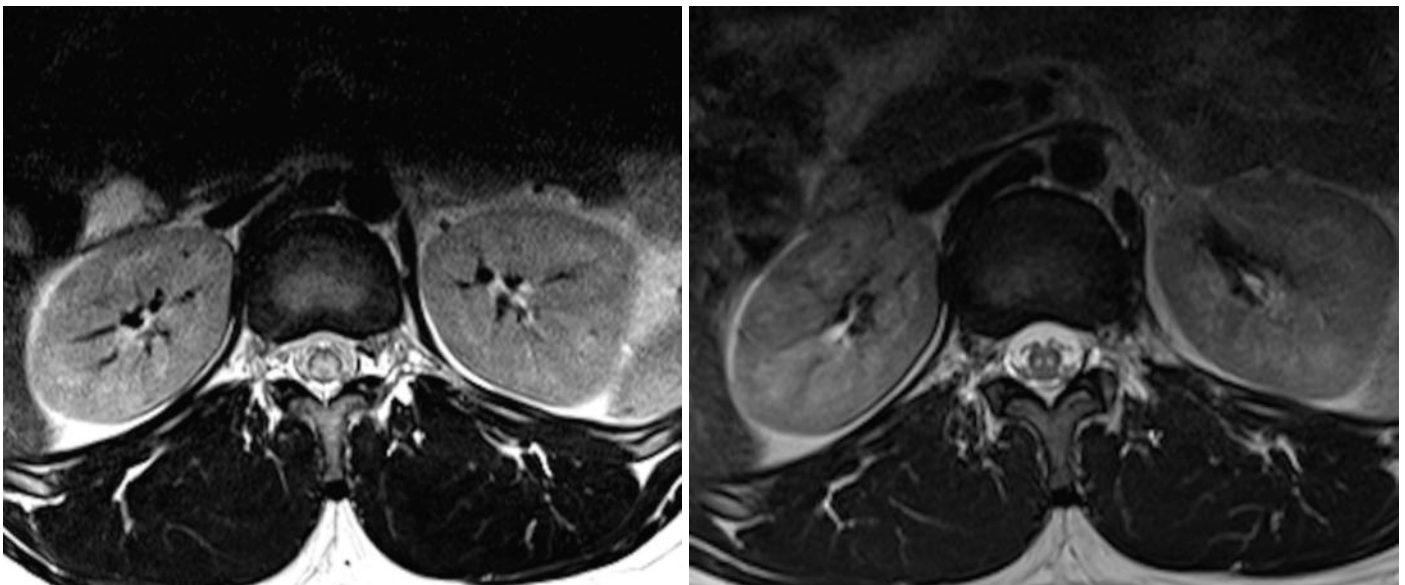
MRI comparison of the distal spinal cord during hospitalization and at 4-month follow-up. Axial T2W image obtained at the time of hospitalisation (A) reveals significant cord expansion and abnormal hyperintensity within the cord. Axial T2W image of the distal cord four months later reveals significant regression of the signal abnormality and resolution of the previously noted cord edema (B).
